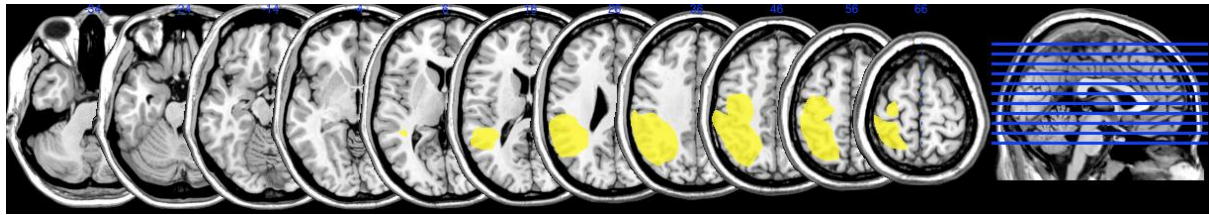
MRI scan of patient AVG
